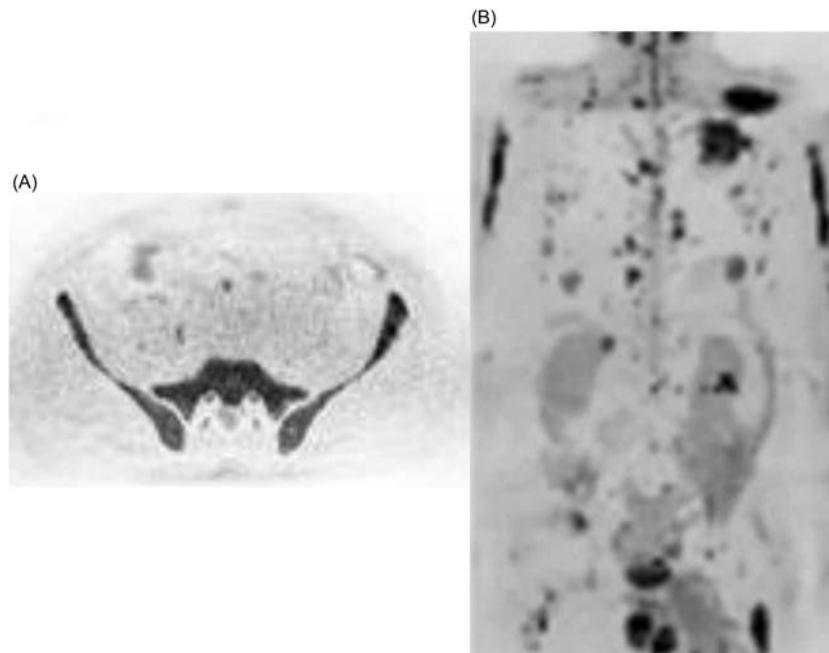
Diffusion-weighted imaging (DWI) in plasma cell diseases. A transverse section at the level of the pelvis shows a diffuse infiltration pattern (A). A frontal projection image in a patient with a multifocal infiltration pattern, with lesions (B), for example, in the left scapula, left upper chest wall, both humeri, left femur, and numerous others.
